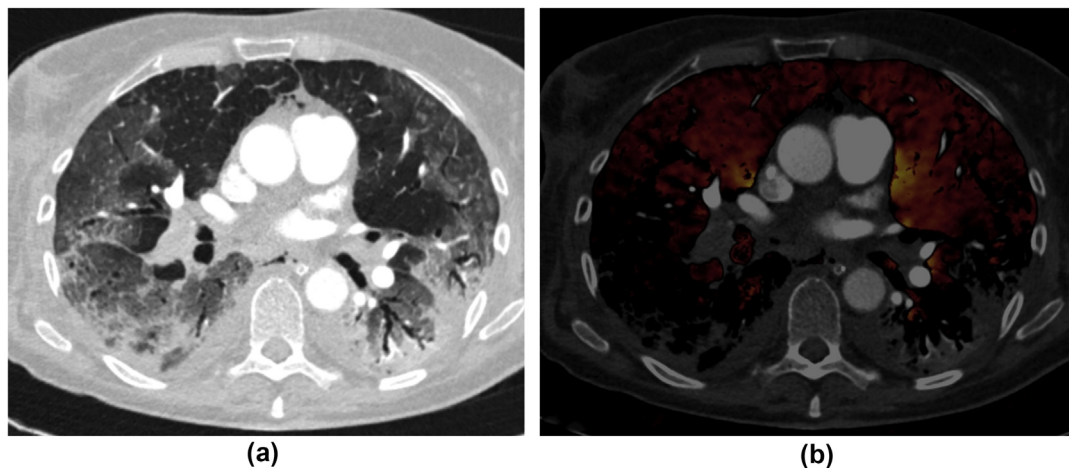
(a) Transverse chest CT image in lung window of a 45-year-old woman with COVID-19 pneumonia demonstrates mixed consolidation and ground glass in the bilateral lower lobes along with multifocal ground-glass opacities in the upper lobes. (b) At the same anatomical level, the transverse MDI image (a fused image of lung perfusion overlaid on conventional CT image in a soft-tissue window) depicts large pulmonary emboli in the right lower lobar and segmental arteries. The decreased perfusion in the right lower lobe is attributed to a perfusion defect from occlusive PE. The lack of perfusion in the left lower lobe without corresponding PE is artefactual as regions with consolidation are excluded from evaluation.
